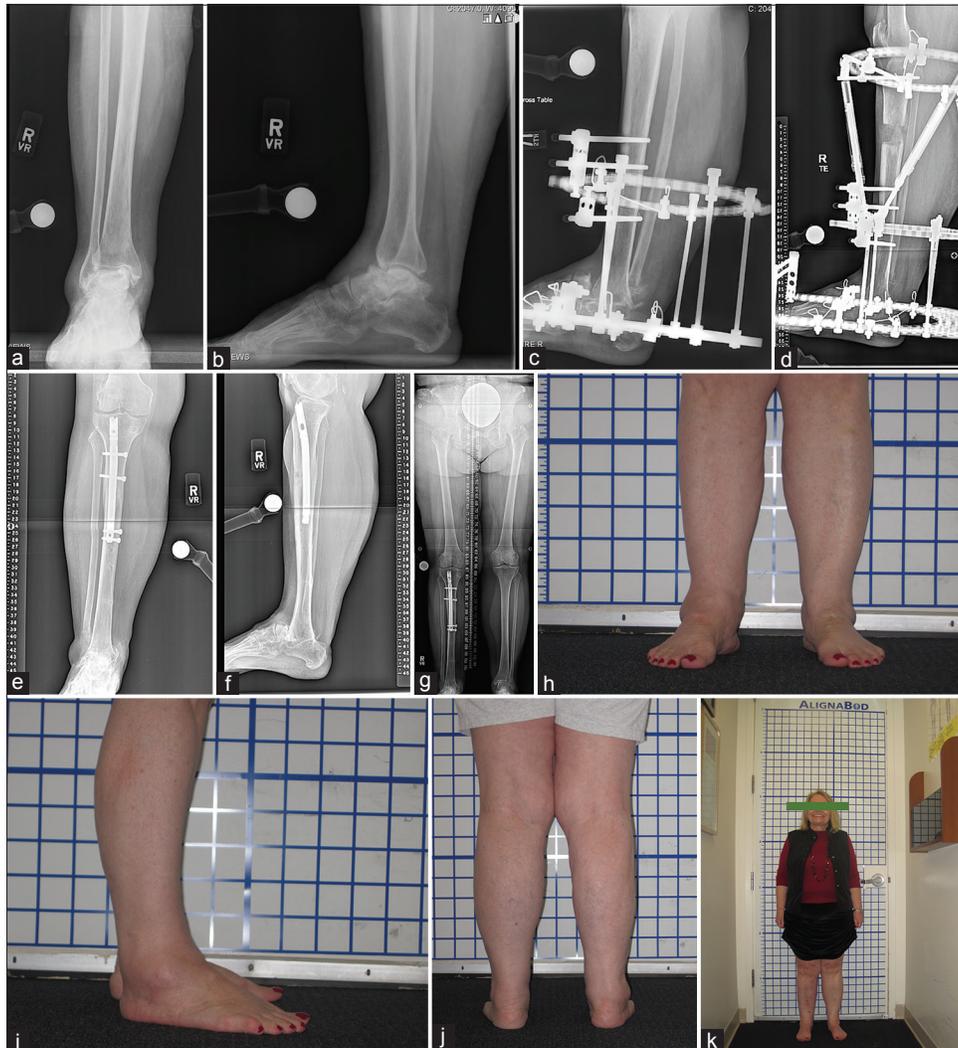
A 65-year-old female with extensive osteonecrosis of the talus. (a) AP X-ray of the right ankle. (b) Lateral X-ray of the right ankle. (c) Lateral X-ray showing a tibiocalcaneal fusion using circular external fixation after excision of the talus, 1 month after surgery. (d) Lateral X-ray following staged tibial lengthening and displaying the final distraction gap. The proximal ring was placed using LATN technique. (e) Anterior-posterior X-ray showing healed tibiocalcaneal fusion and lengthening site, with an intramedullary nail present as part of the LATN technique, 11 months after surgery. (f) Lateral X-ray. (g) Standing bipedal X-ray showing optimized leg lengths 11 months after tibiocalcaneal fusion and LATN. (h) Front view of the patient's ankles and legs, 2 years after tibiocalcaneal fusion and optimization of leg lengths. (i) Side view of the patient's ankles and legs, (j) Clinical photograph Rear view of the patient's ankles and legs. (k) Overall view of the patient's legs
